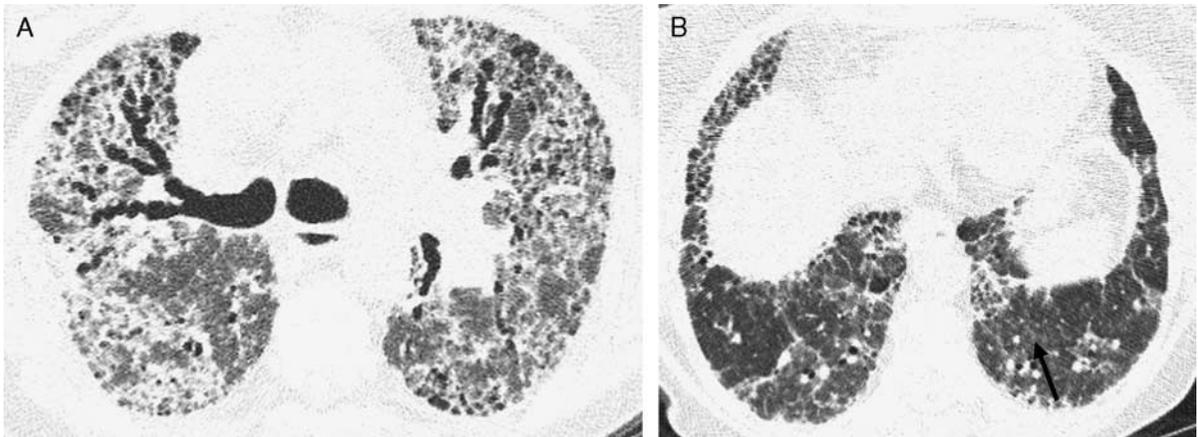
A and B, Distribution of fibrosis in HP. HRCT in a patient with chronic HP shows honeycombing, reticulation, and traction bronchiectasis. Note the lack of a subpleural distribution of findings (A). Also, the fibrosis shows relative sparing of the lung bases and is associated with ground-glass centrilobular nodules (arrow) and mosaic perfusion (B).
